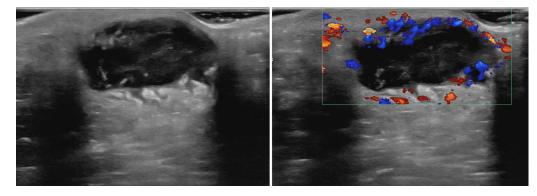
Point-of-care ultrasound demonstrating a fluid collection. The image on the right demonstrates surrounding hyperemia with no Doppler flow within the fluid cavity.
